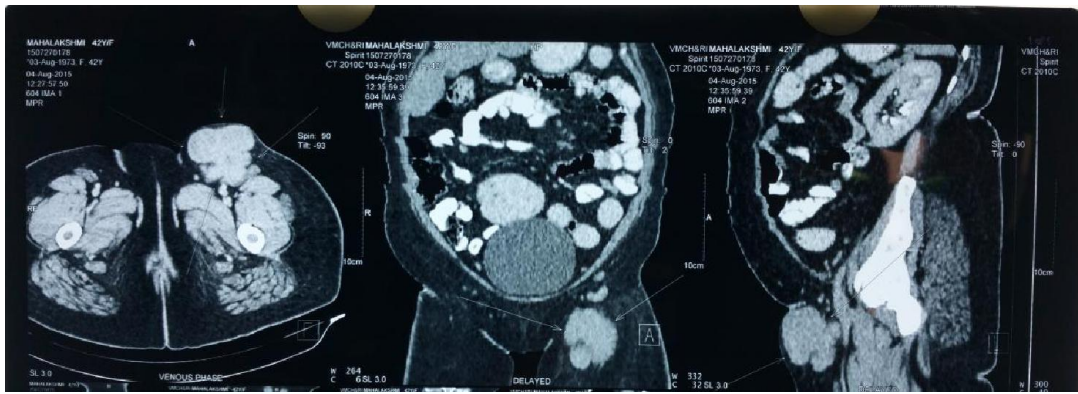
CT picture showing tumour
